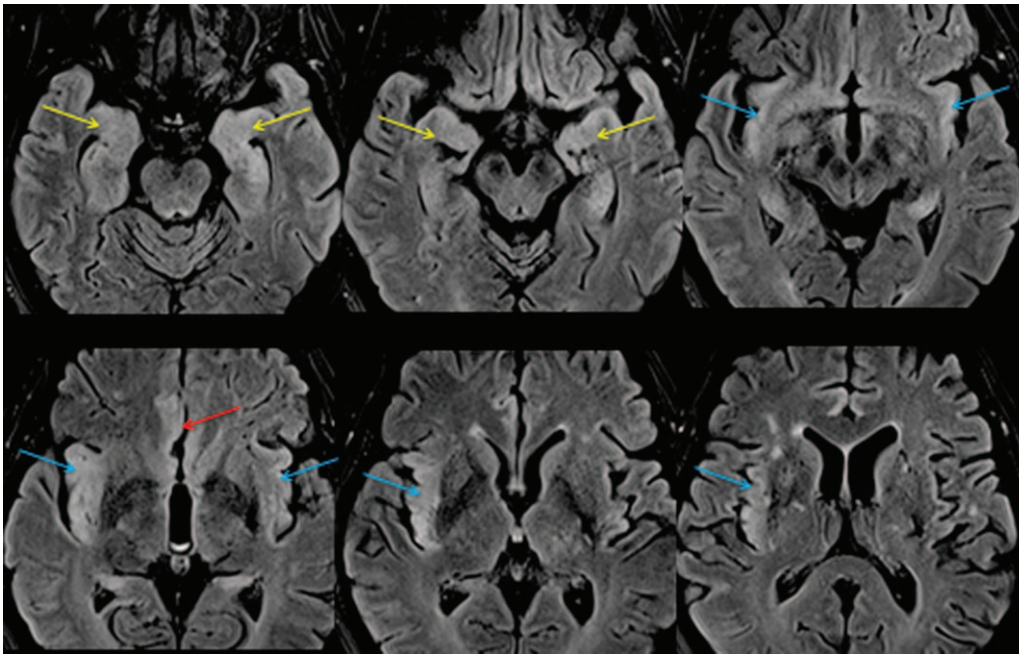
Mesial temporal lobes (yellow arrows), cingulate gyrus (red arrows), and insulae (blues arrows) involvement with asymmetric (right > left) cortical thickening and FLAIR hyperintensity.
